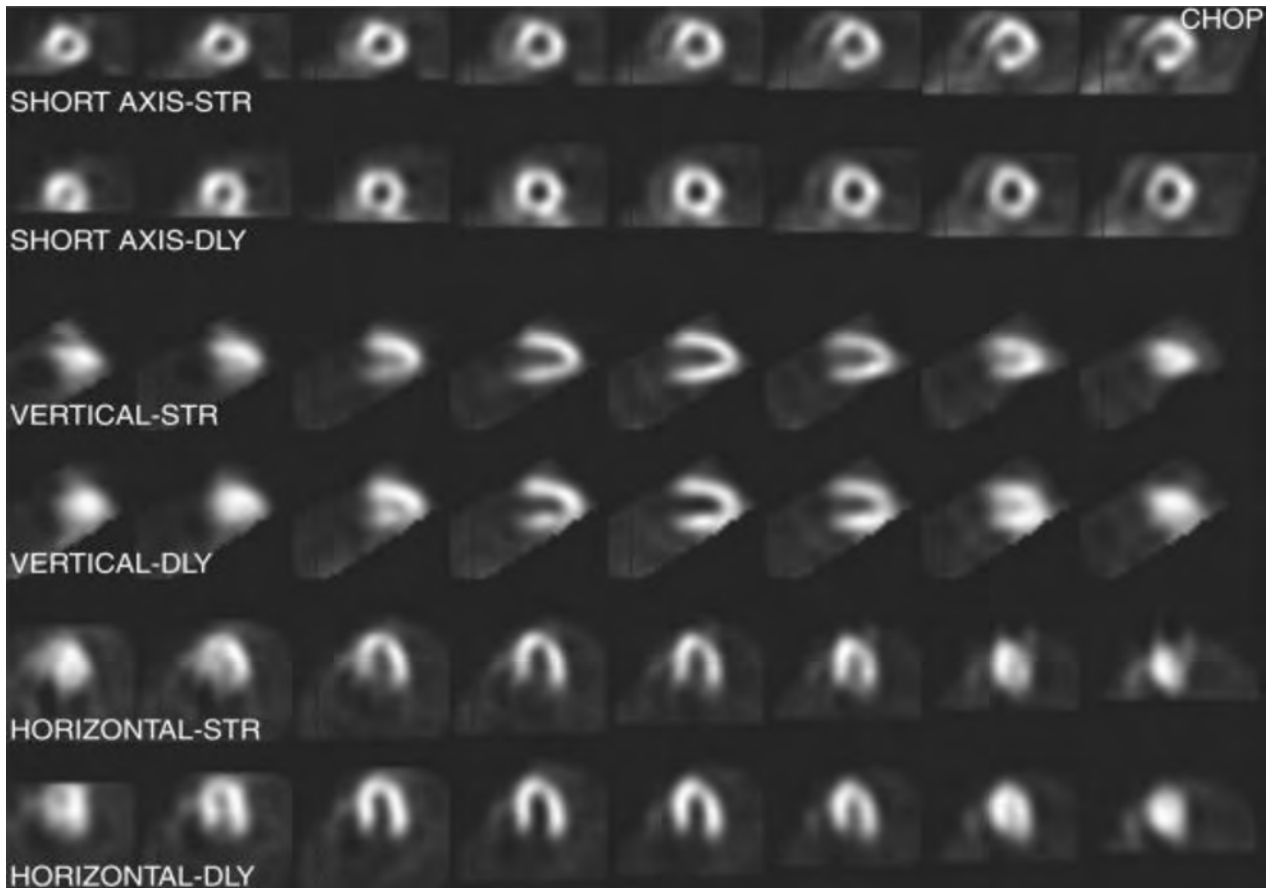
This is a typical display of single-photon emission computed tomographic resting and stress images for myocardial perfusion. Resting and stress images are displayed in the short, vertical, and horizontal axes. This image shows a reversible perfusion defect in the right CA. Note the decreased uptake of isotope in the short-axis stress image compared with the resting images.
